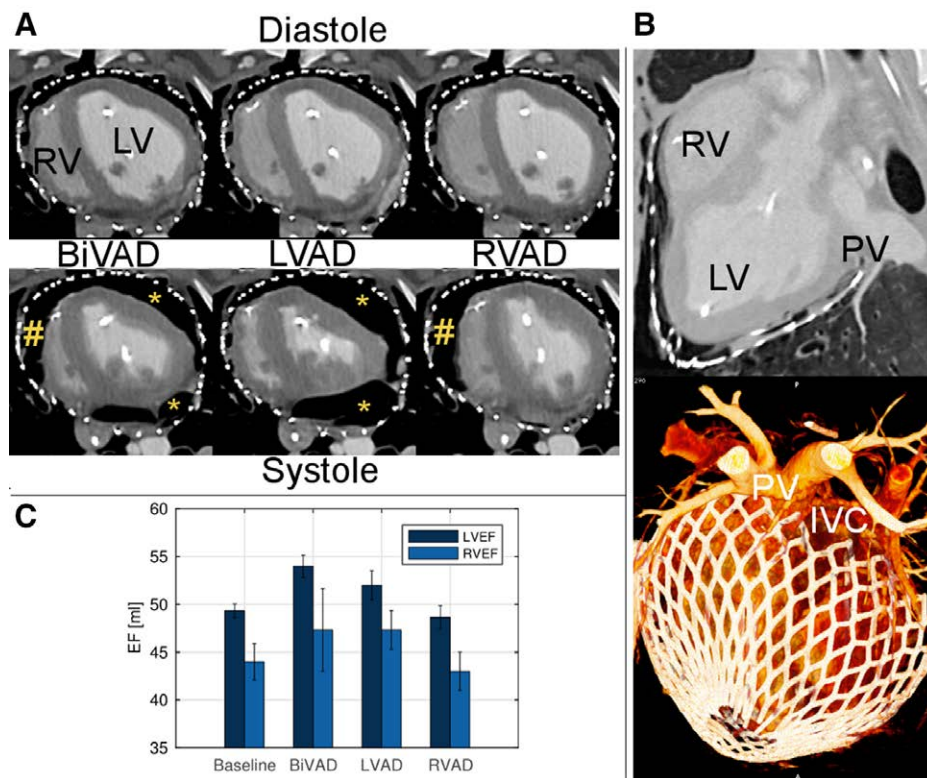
Postimplant computed tomography (CT) images. The effects of biventricular assist device (BiVAD), left ventricular (LV) assist device (LVAD) and right ventricular (RV) assist device (RVAD) support are shown in the end-diastolic and end-systolic phase. # indicates RV unit, * indicates LV units (A). In (B), the device fit is shown in sagittal view. A three-dimensional (3D) volume rendering shows the importance of the anatomic correct positioning of the device with regards to the major vessels. C: Ejection fraction (EF) from left and right ventricular CT volumetry. IVC, inferior vena cava; PV, pulmonary vein. [full color online](#)
